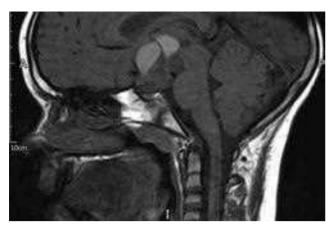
Sagittal T1-weighted MR image of the pituitary and supra-sellar region of a patient with a large craniopharyngioma. The optic chiasm is compressed to the extent that it cannot be clearly distinguished on the surface of the tumour
